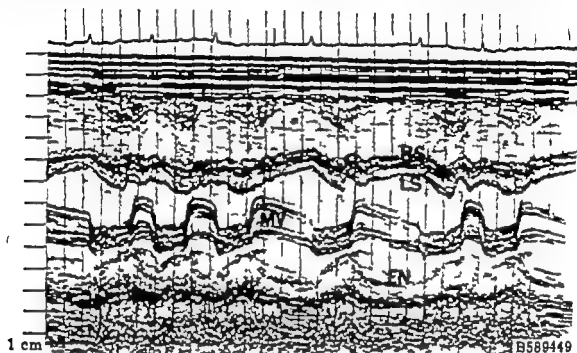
M-mode echocardiogram from the patient with mitral stenosis demonstrating the typical echocardiographic features of the stenotic mitral valve. There is an increase in echo production from the diseased anterior and posterior leaflets, decrease in opening amplitude of the anterior leaflet, anterior motion of the posterior leaflet during diastole, and a decrease in the diastolic or E to F slope. RS = right side of the interventricular septum, LS = left side of the interventricular septum, NV = mitral valve, EN = posterior wall endocardium.
